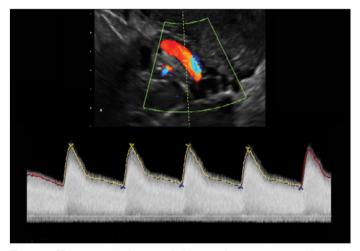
Transvaginal ultrasound showing the uterine artery Doppler The uterine artery is identified by color Doppler flow mapping and Doppler velocity waveforms. When three similar consecutive waveforms were obtained, the automatic mean pulsatility index (PI) of the left and right uterine arteries was measured, and mean PI Doppler was calculated.
